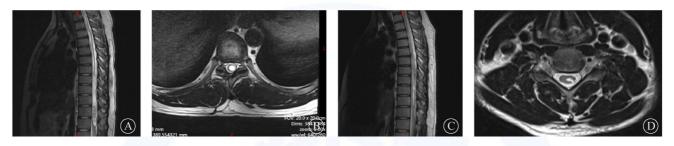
Preoperative and postoperative MRI images of syringomyelia patient
